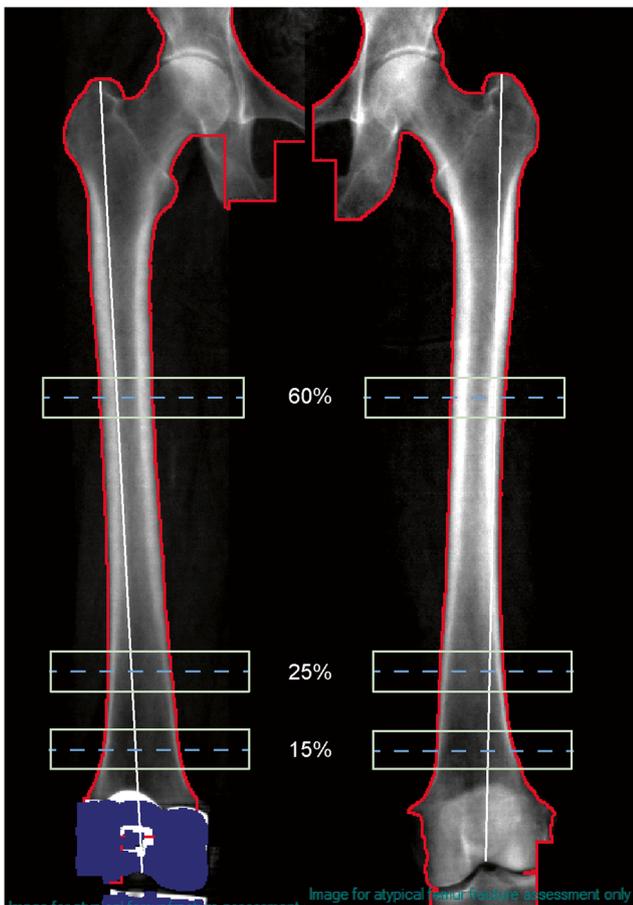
Custom regions of interest. Distal femur ROI placement is depicted; this was determined by using the DXA software line tool to measure the femur length from the greater trochanter to intercondylar notch on the non-operated leg. Distances from the notch were calculated for 15%, 25%, and 60% of the femur length (dotted lines). A 2-cm ROI was manually centered at these points. Cortical width was measured by the AFF feature of the DXA software at the center of these 2-cm ROIs (dotted lines). This pattern was replicated on the TKA femur and copied to the duplicate scan for precision assessment. ROI region of interest, DXA dual-energy x-ray absorptiometry, AFF atypical femur fracture, TKA total knee arthroplasty
